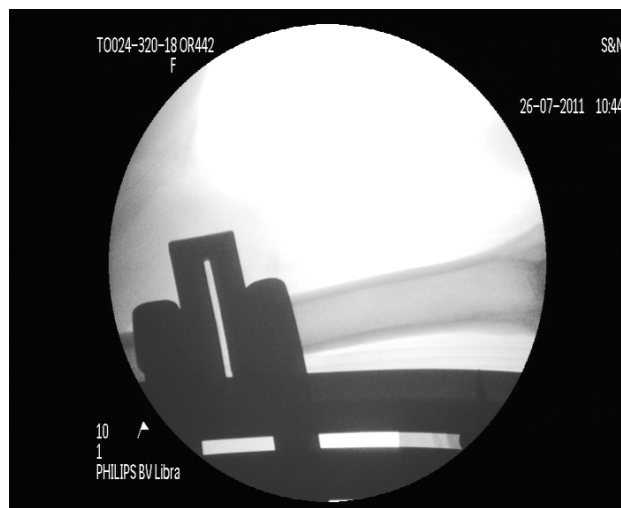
X-ray fluoroscopic image acquired from the diaphyseal region of the tibia indicating the position of the osteotomy
